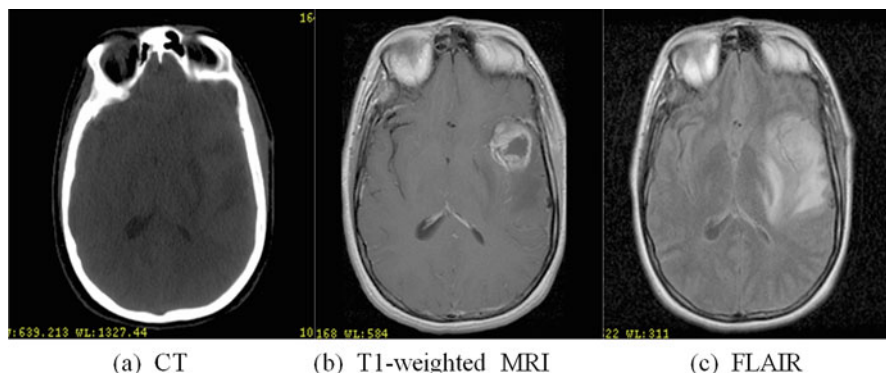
Images of a representative case taken by (a) CT, (b) T1-weighted MRI, (c) FLAIR (Pictures from https://www.aapm.org/meetings/06ss/documents/2006summerschoolIIGRTIntro_000.pdf)
